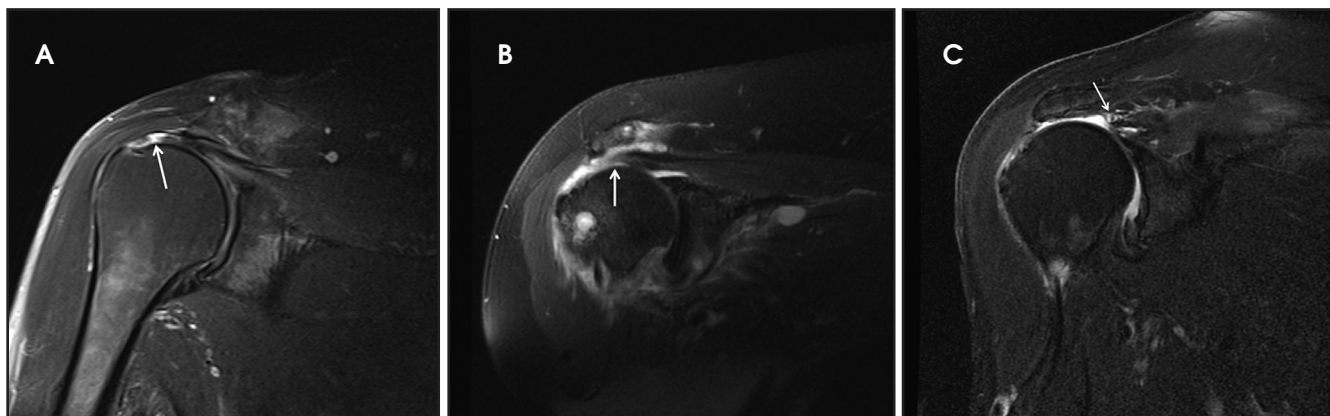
(A) Coronal oblique T2-weighted (T2W) images demonstrate full thickness tears (arrow) near the humeral insertion, (B) with tendon retraction to the level of the humeral dome (arrow), and (C) with tendon retraction to the level of the glenoid (arrow).
